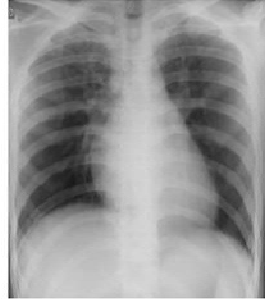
Post-treatment X-ray
